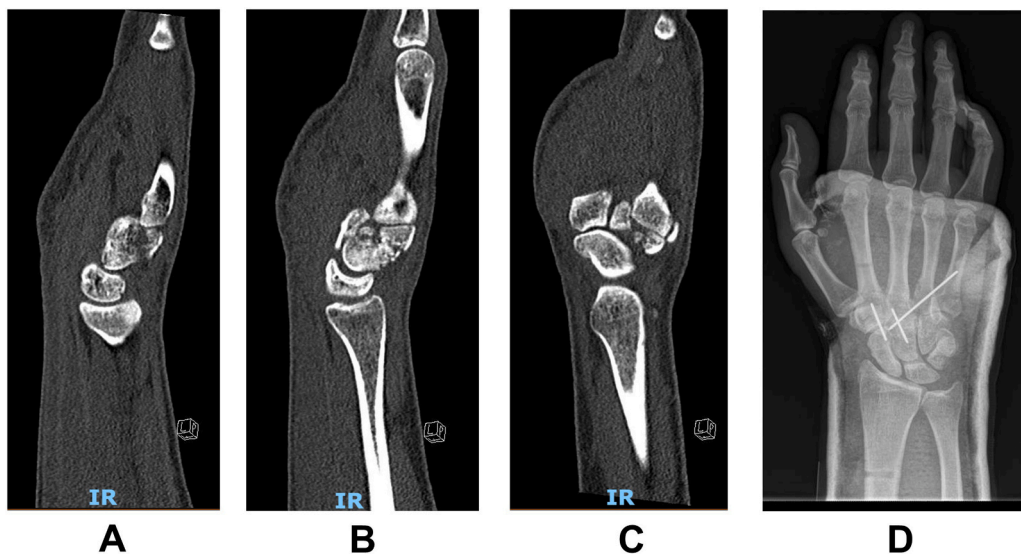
Panel A: Sagittal CT-view of right hand, showing hamate fracture.
